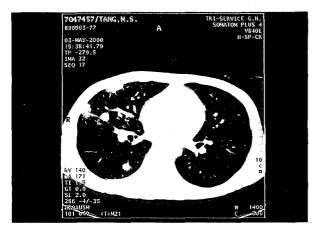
High resolution CT shows larger solid nodules and pleural-based nodules.
